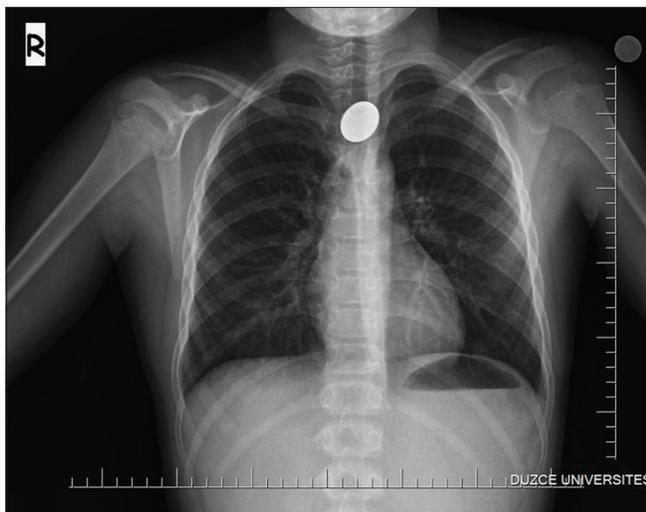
X-ray of our patient who swallowed a coin
